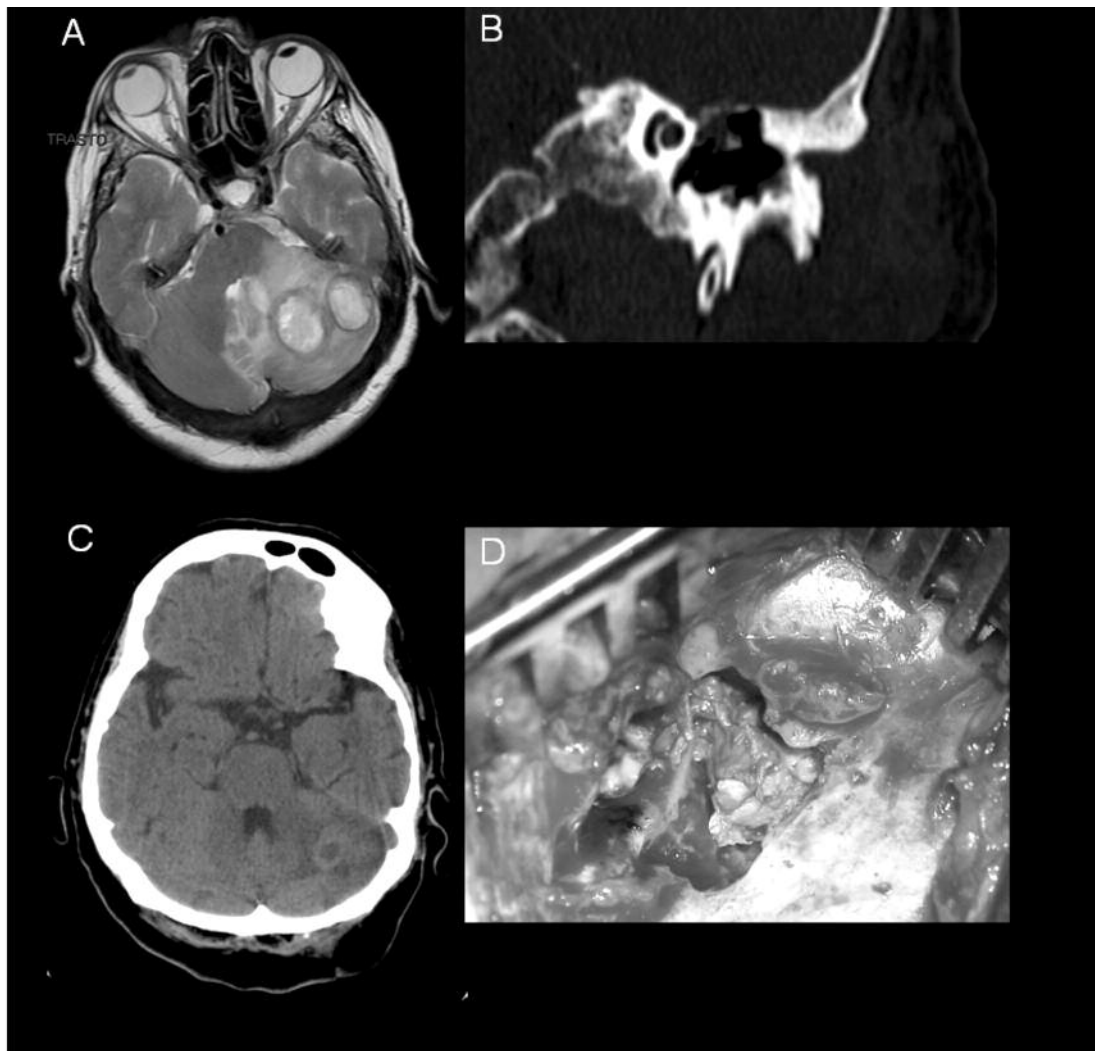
Brain MRI axial (A) scans showing multiple coalescent ring enhancing lesions in the left cerebellar hemisphere with a fluid signal value at the T1 and T2 sequences.
